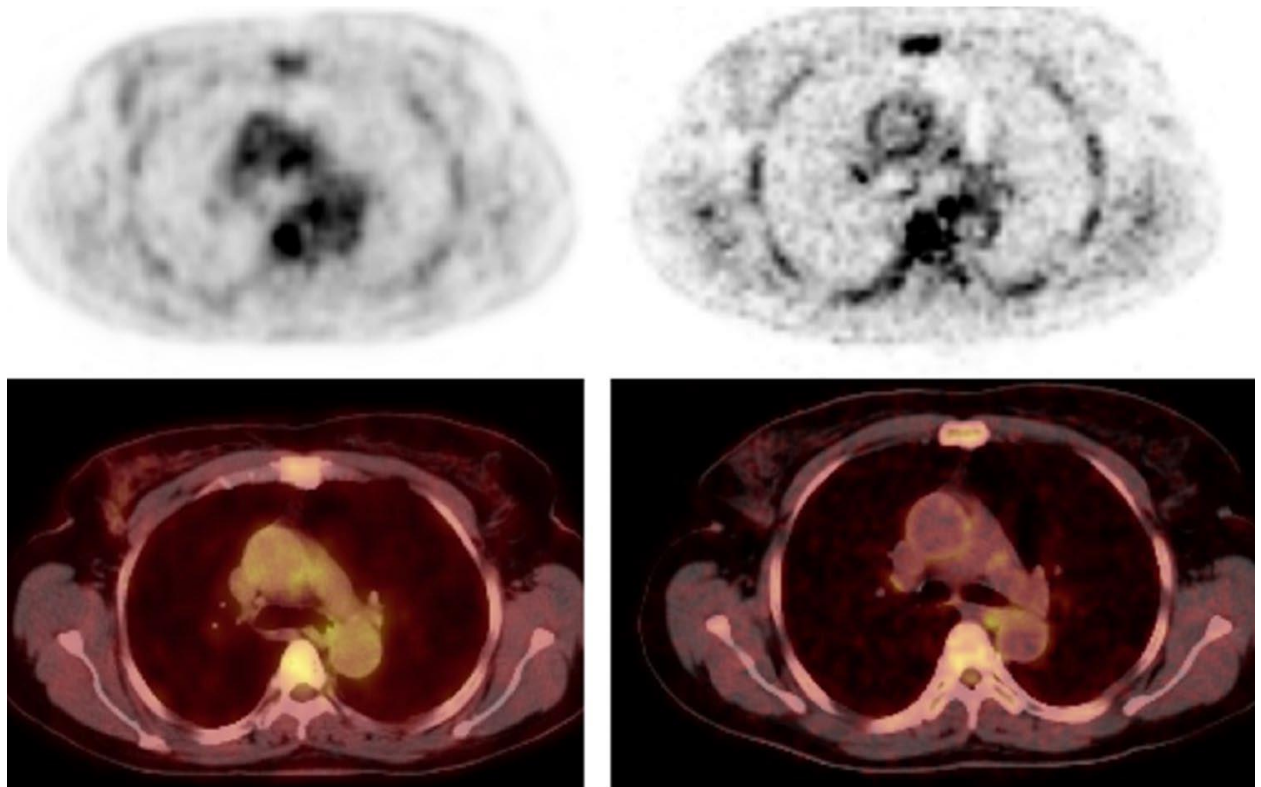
A 54-year-old female had dual-time points ^{18}F -FDG PET/CT imaging. Early imaging acquired at 60 min post-tracer injection using the routine oncologic PET parameters shows high blood-pool background activity (right images). Delayed imaging acquired at 124 min post-tracer injecting using PET parameters dedicated for vascular inflammation imaging showed good background activity clearance with improvement in arterial wall ^{18}F -FDG uptake (left images). Dual-time point imaging was acquired in this patient to show the improvement of arterial
